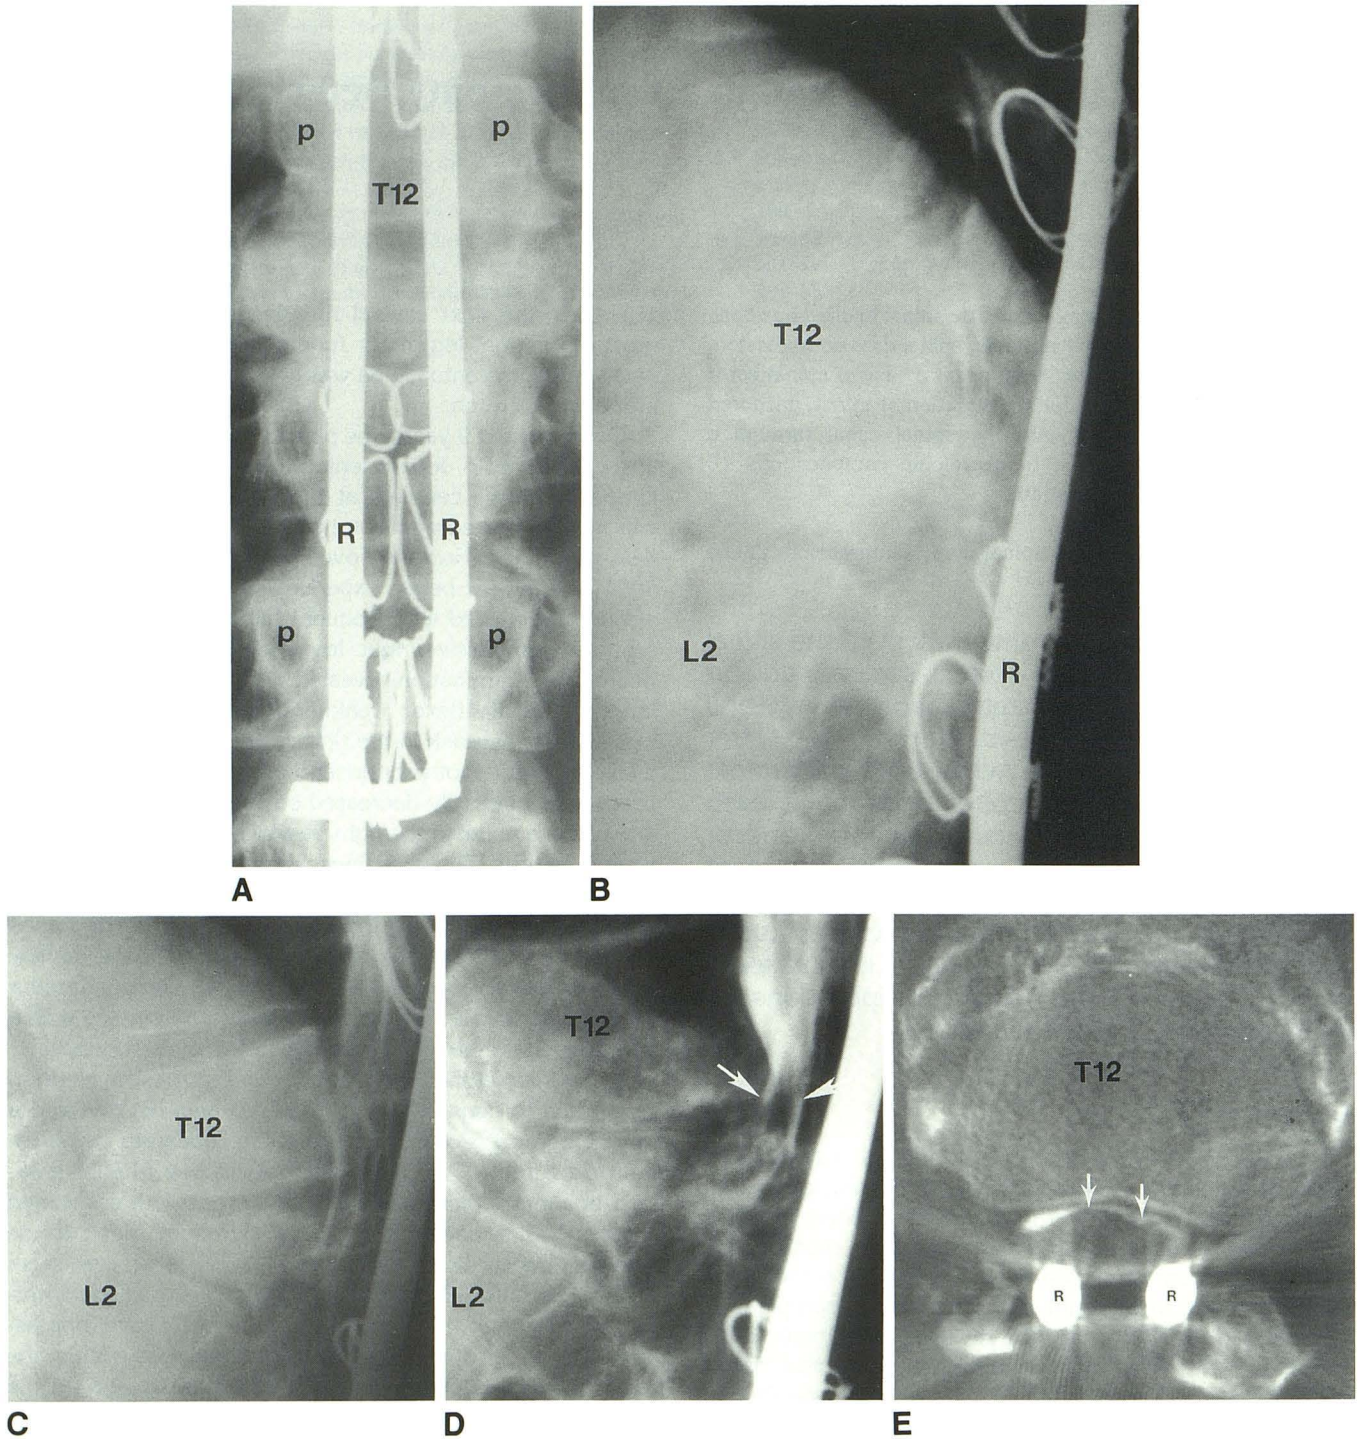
Twenty-six-year-old man 10 years after traumatic L1 compression fracture treated by L1 laminectomy and bony posterior spinal fusion with Luque rod instrumentation. Immediate postoperative anteroposterior radiograph of the spine (A) demonstrates two Luque rods that are appropriately anchored, but are located in a more medial than usual position (medial to the pedicles) such that they appear to overlie the laminectomy defect. Kyphosis (as measured from the superior end plate of T11 to the inferior end plate of L2) centered at the L1 level progressed from 22° in 1982 (B) to 40° in 1985 (C) to 50° in 1990. Progressive retrolisthesis of T12 is also noted. Myelogram (D) with postmyelogram CT (E) in March 1991 redemonstrates the 50° kyphosis and shows migration of the Luque rods into the spinal cord canal through the laminectomy defect causing a posterior extradural myelographic block and thecal sac compression. (L2 = L2 vertebral body; P = pedicle; R = Luque rod; T12-T12 vertebral body; arrows = compressed thecal sac.)
